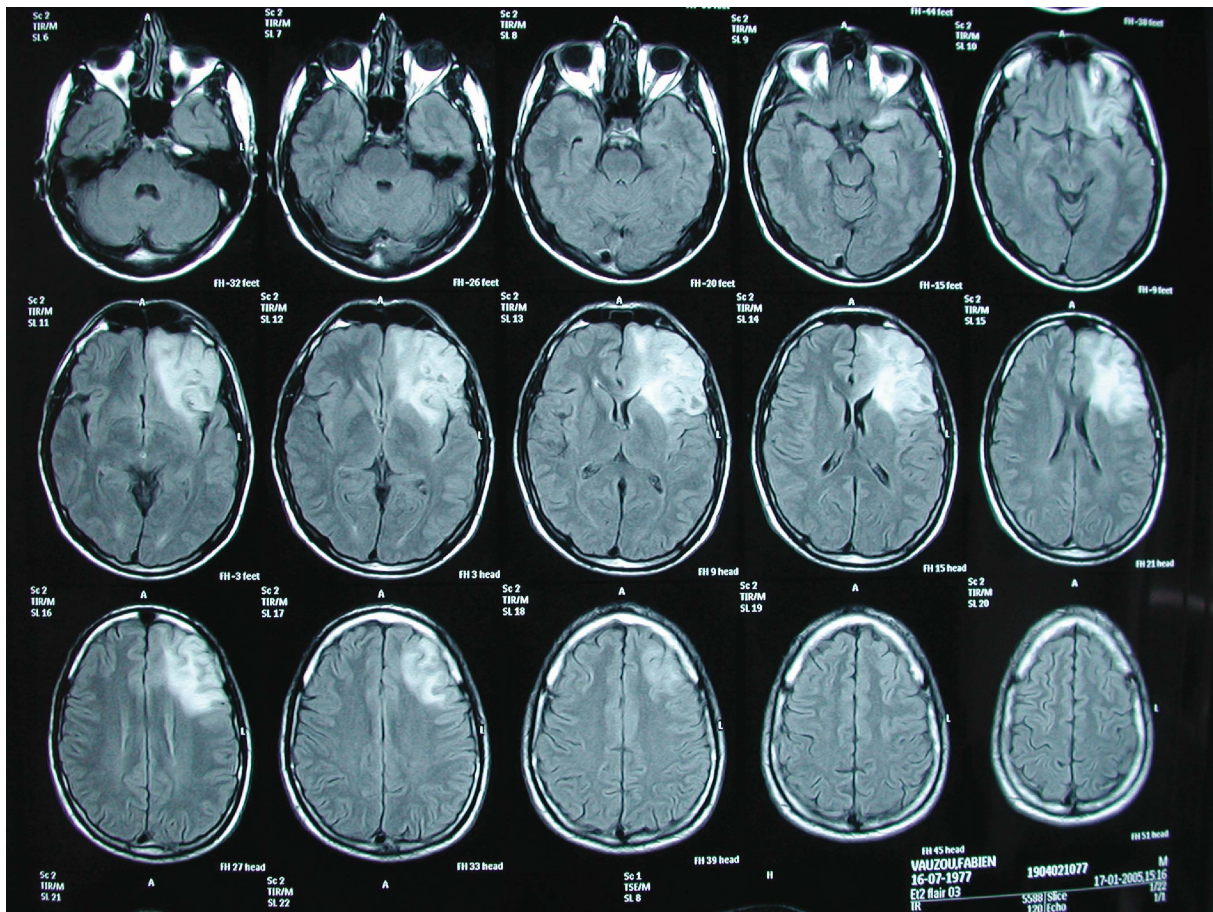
Post resection MRI shows that the resection concerned the left frontal lobe, notably the pars triangularis, the pars orbitalis and the anterior part of the pars opercularis.
